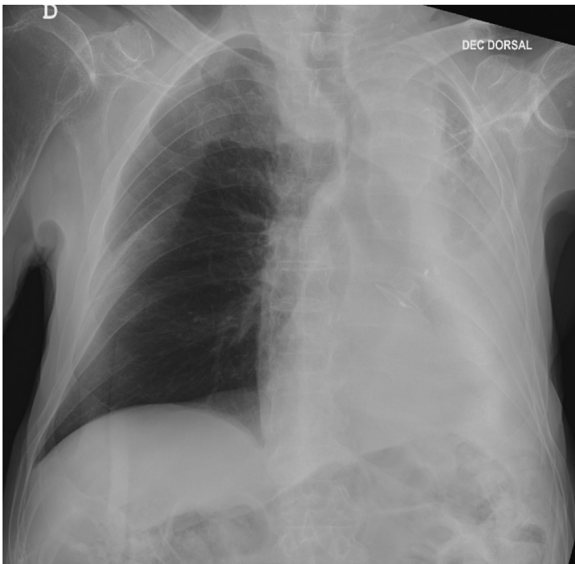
Admission chest X-ray.
